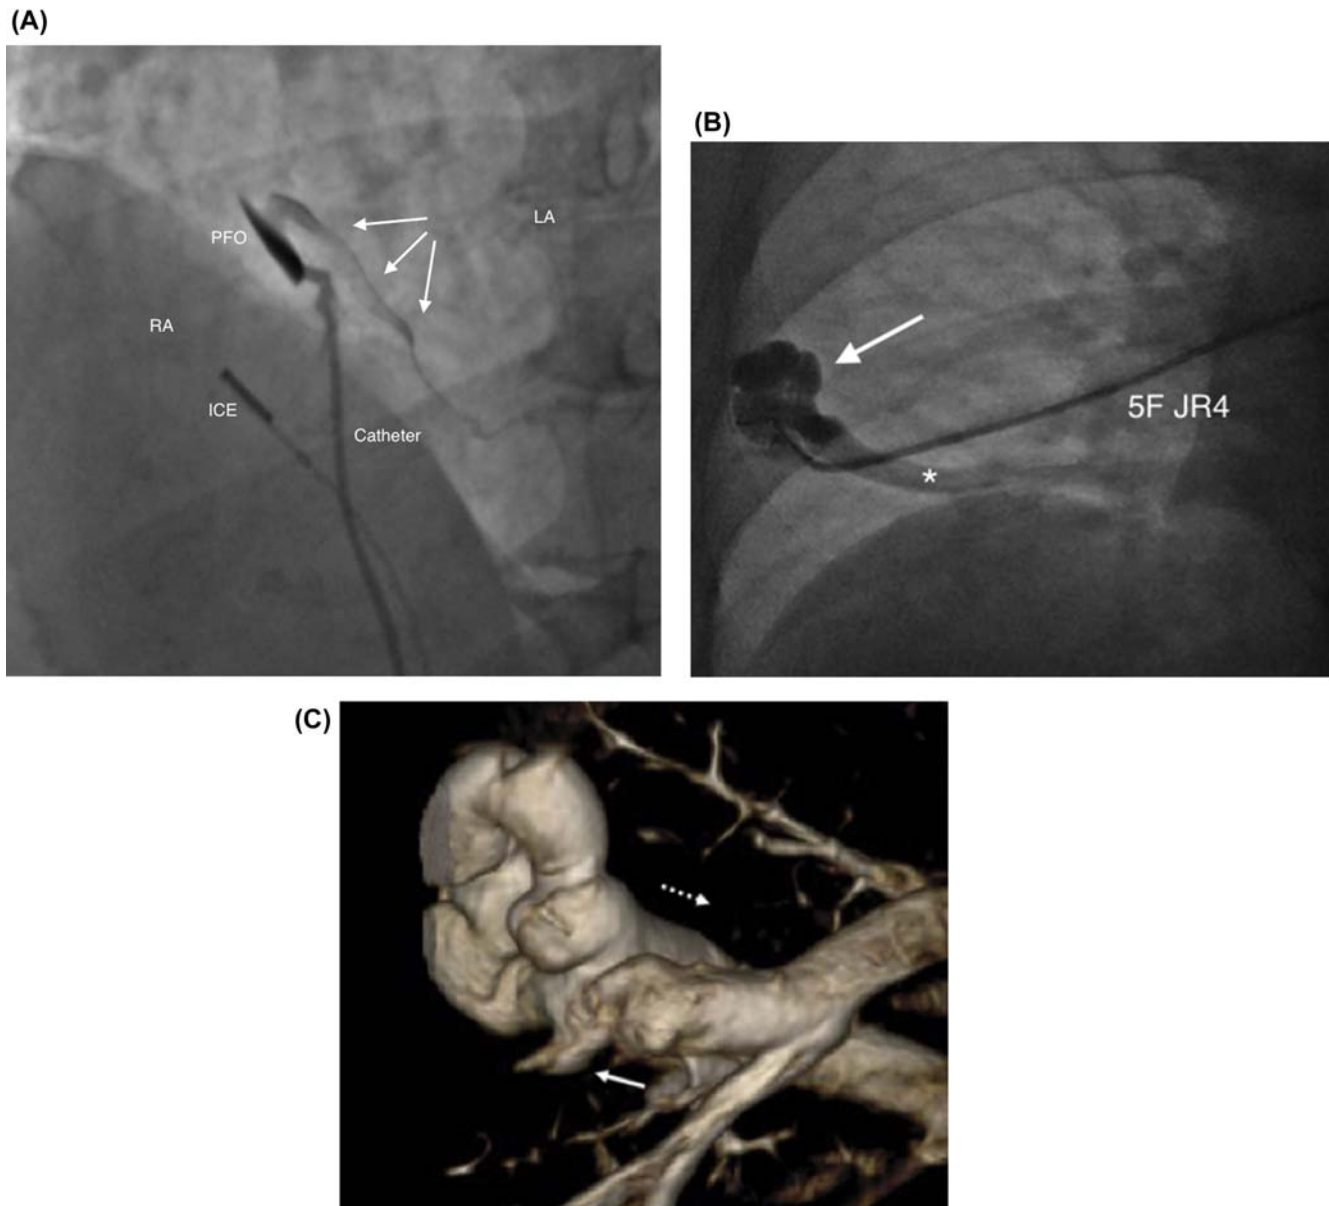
(A) Contrast medium injection through a PFO showing its opening is narrow, which must be accounted for when choosing the device size. Arrows show contrast flowing freely into the left atrium (LA) from the right atrium (RA). ICE, intracardiac echocardiography. (B) Fluoroscopic image for a 5F JR4 catheter selective into a subsegmental pulmonary artery, opacifying the arteriovenous malformation (denoted with an arrow) and contrast returning via a pulmonary vein (with an asterisk). (C) A subsequent 3D reconstruction from a computed tomography scan of the arteriovenous malformation in (B). Solid arrow depicts flow into the arteriovenous malformation and the dotted arrow shows flow away through a pulmonary vein.
